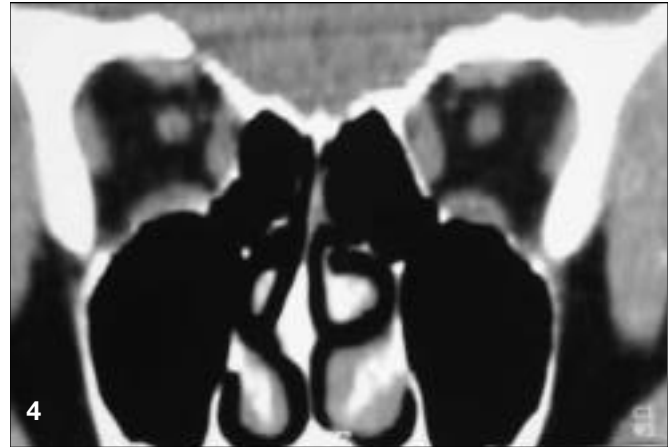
CT scan showing a ipsilateral mucosal turbinate hypertrophy.
